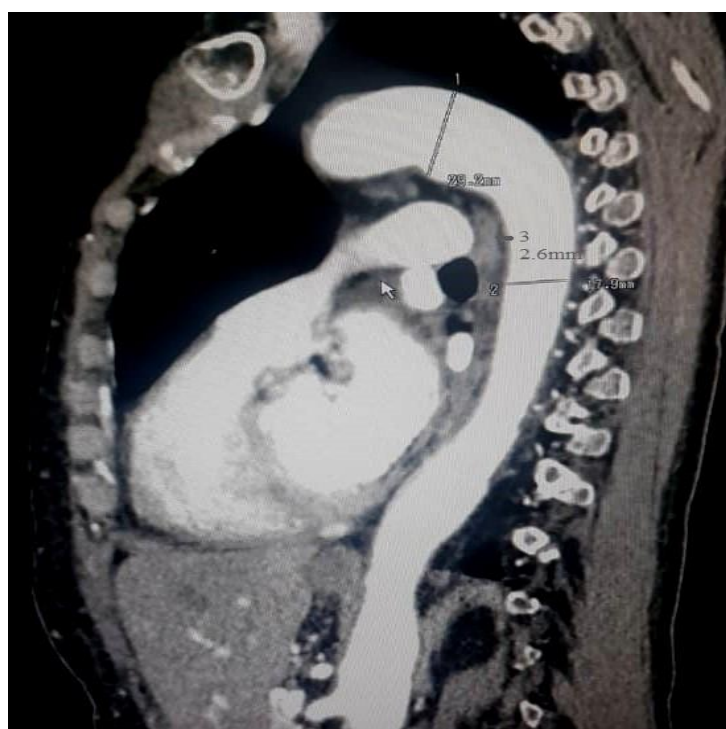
Segment of thoracic aorta on Computed Tomography
